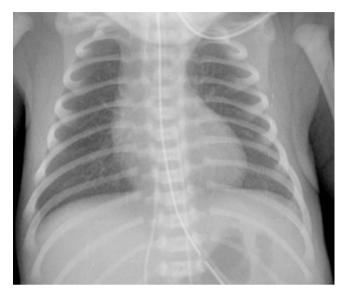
Chest X-ray demonstrating normal cardiac size and oligemic lung fields
